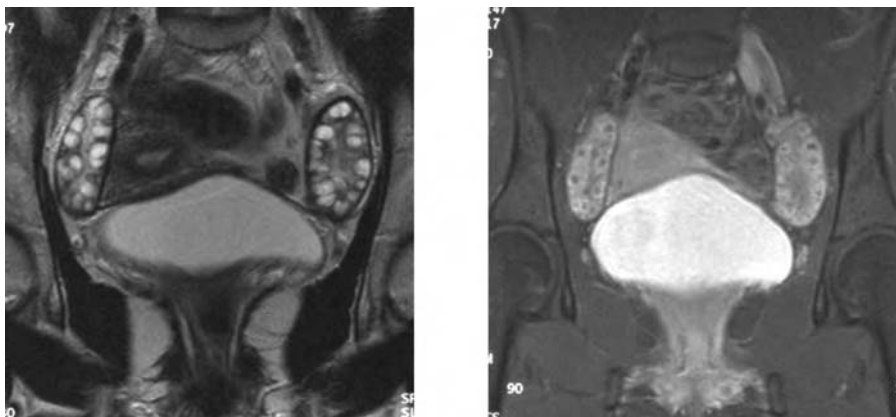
PCOS: magnetic resonance image after gadolinium injection.
